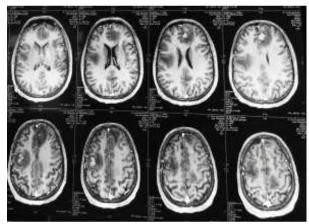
CT Brain showing multiple tuberculomas with peri-lesionaledema
